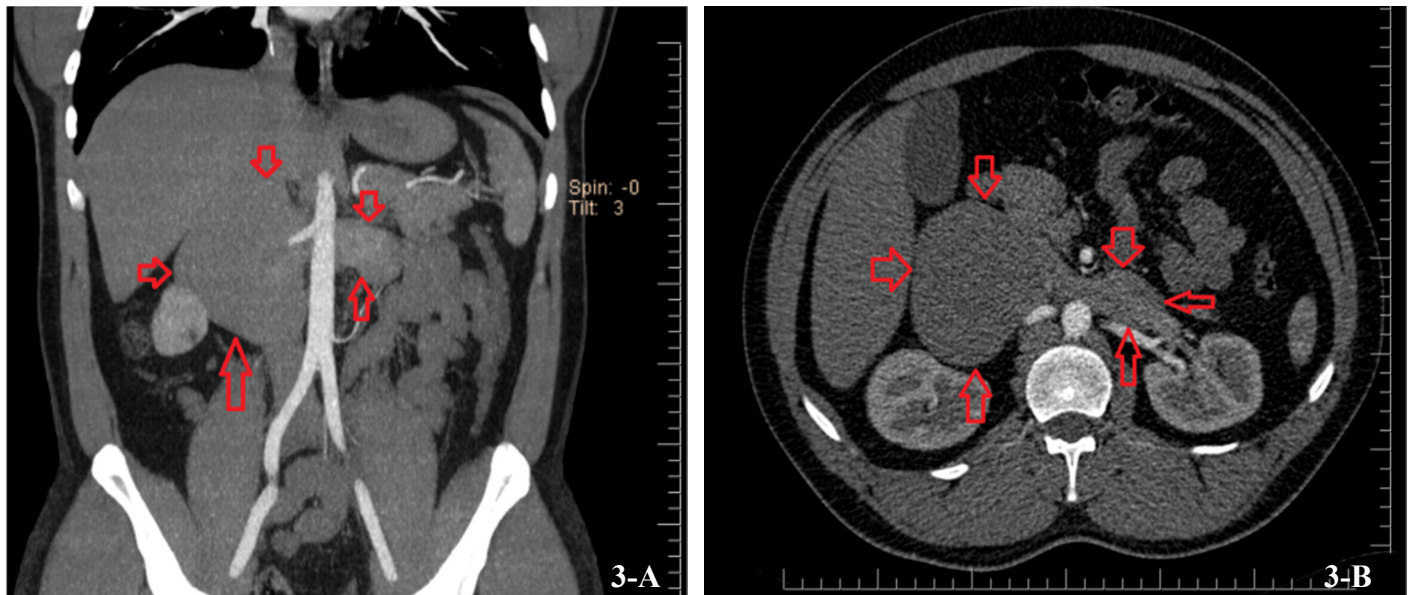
A-B. January 2018 CTA
